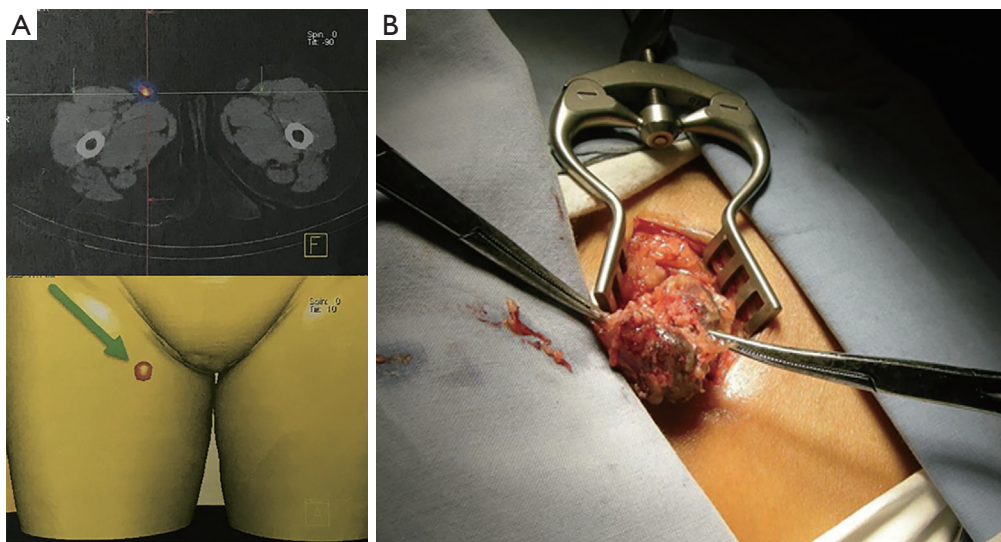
Detecting and harvesting the ^{99m}Tc -rituximab marked SLN. (A) The lymphoscintigraphy of location (arrow) and number of SLN; (B) a minimal incision was made to acquire the SLN. SLN, sentinel lymph node.
